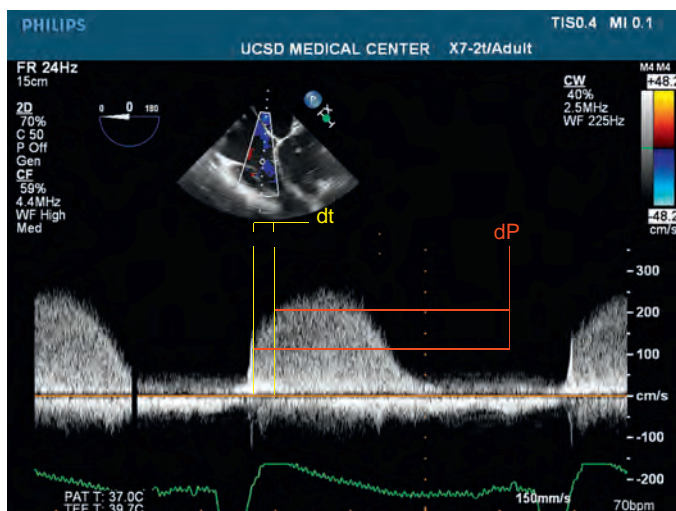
Spectral Doppler analysis of the tricuspid regurgitation jet shows how to perform the calculation of derivative of pressure measured over time (dP/dt). Flow velocities of 1 and 2 m/sec are marked, and the time interval between them is measured, converting milliseconds to seconds. The change in pressure in this case is $16 - 4 = 12$ mm Hg. dP/dt is calculated as 12 mm Hg/time (in seconds). Values less than 400 mm Hg/sec suggests right ventricular dysfunction.
